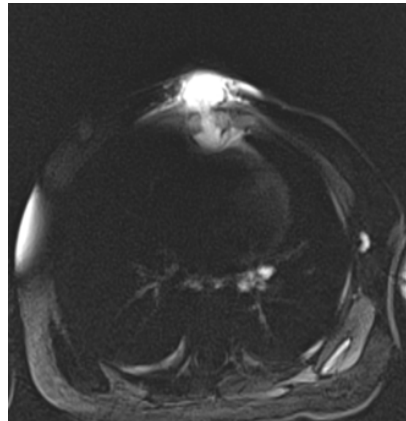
Magnetic resonance imaging sternum axial.
